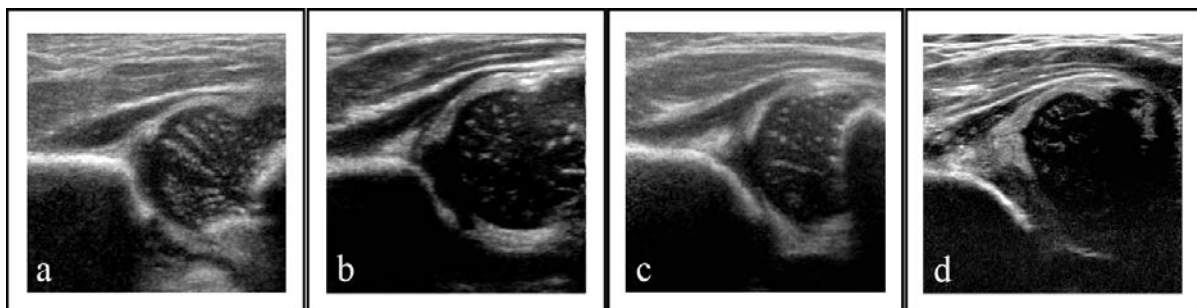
Sonographic assessment of hip morphology in newborns, using Grafs standard coronal view and the alpha angle. Each hip is morphologically classified as a) normal ($\alpha \geq 60^\circ$), b) immature ($50^\circ \leq \alpha < 60^\circ$), c) mildly dysplastic ($43^\circ \leq \alpha < 50^\circ$) or d) severely dysplastic ($\alpha < 43^\circ$) (Rosendahl's classification).
